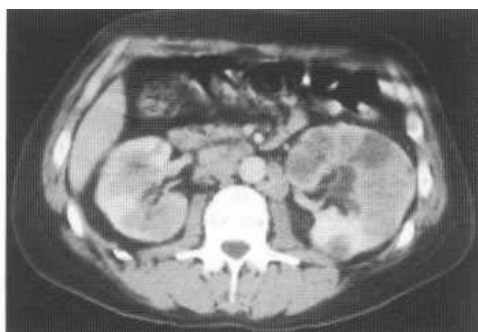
Renal lymphoma on postcontrast CT. There are bilateral relatively well-defined intermediate to low-density deposits of lymphoma.
